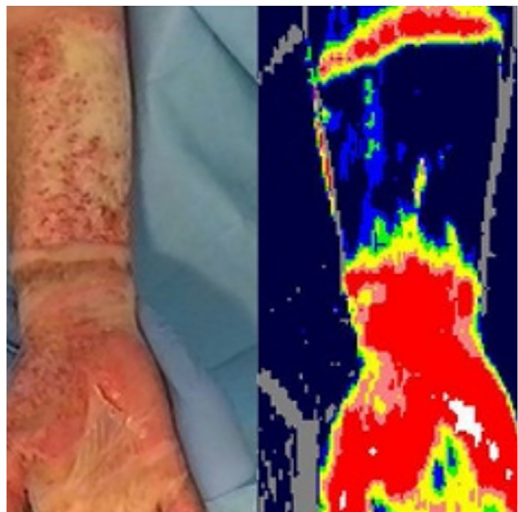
Laser Doppler Imaging of a burn wound. Hop, M.J., Hiddingh, J., Stekelenburg, C.M. et al. Cost-effectiveness of laser Doppler imaging in burn care in the Netherlands. *BMC Surg* 13, 2 (2013). <https://doi.org/10.1186/1471-2482-13-2>.
